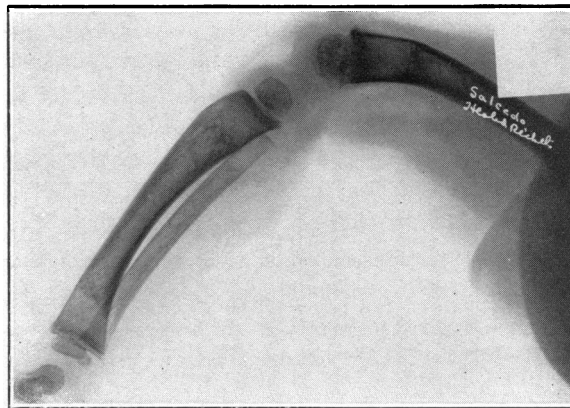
X-ray photograph of the leg of same child as in Fig. 1 (focal distance the same). One can see that the rate of growth of the lower end of the femur is greatest and the rates at the upper and lower ends of tibia and fibula are approximately the same but definitely less than that at the lower end of the femur. The bend backwards of the lower end of the femur at the junction of anti-rachitic and post-rachitic bone means that the epiphysis was dislocated backwards on the diaphysis at the time the rickets was at its height, producing an angular deformity which has mounted higher and higher in the bone with continued growth. If one will compare x-ray pictures of the arm and leg it is possible to see that the rate of growth at the lower end of the femur has been the fastest and at the ends of the tibia and fibula and the upper end of the humerus the rates of growth correspond. At the lower ends of the radius and ulna they are very slightly less.
